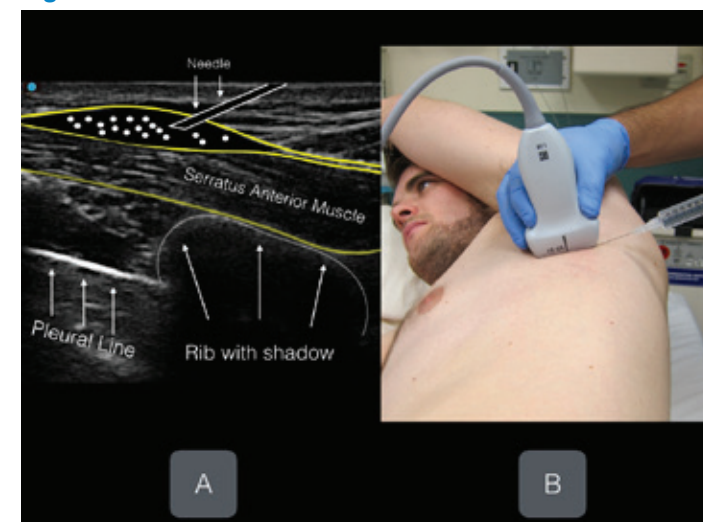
Labeled ultrasound image with corresponding transducer positioning. Note the anterior fascial plane of the serratus anterior muscle. The goal of the planar block is to place anesthetic in this fascial plane.
